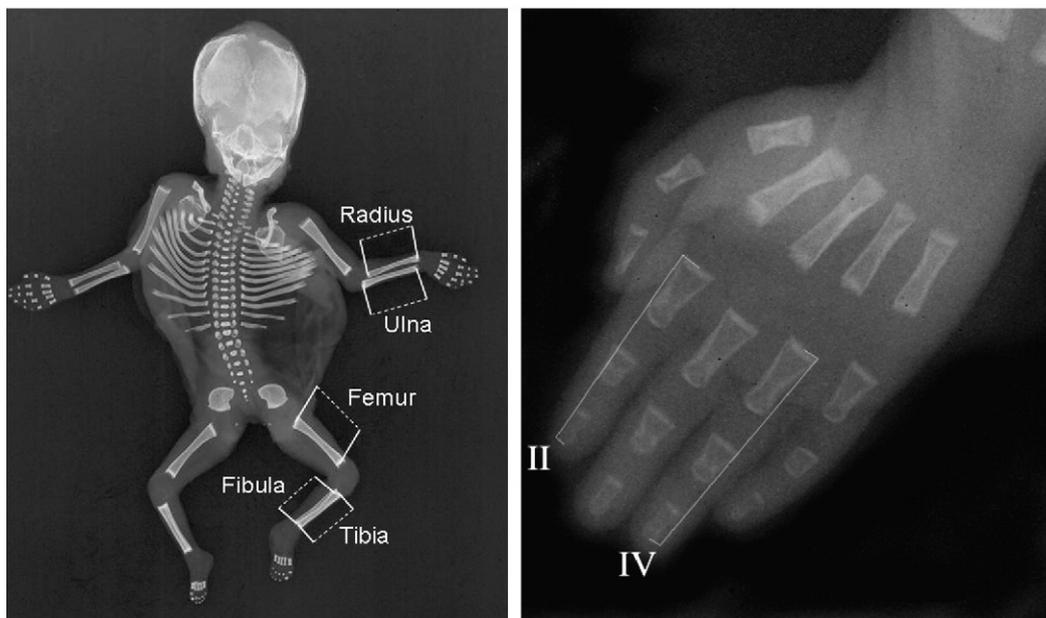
Left: Radiograph of an entire fetus. Lines indicate measurements of limb bones from the midpoint of the proximal end of the bones to the midpoint of the distal end; Right: Radiograph of right hand. Lines indicate length of the midpoint of the proximal end of the proximal phalanx to the midpoint of the distal end of the distal phalanx.
